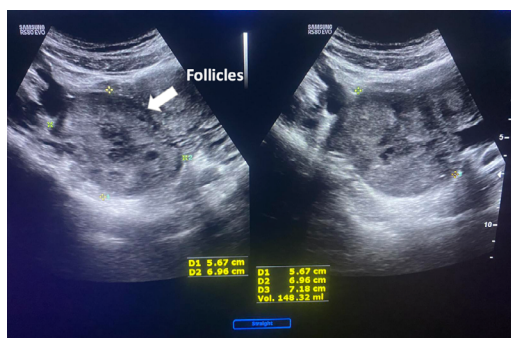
Ultrasound image of left ovary (Bulky left ovary with peripherally arranged follicles)
